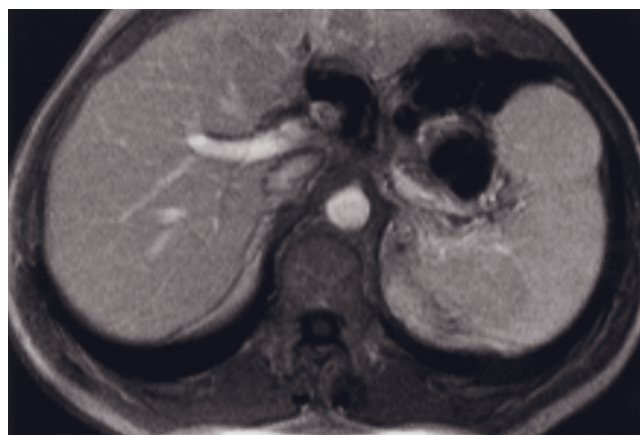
Hamartoma. Coronal T2-weighted single-shot echo-train spin-echo (*a*), T2-weighted fat-suppressed single-shot echo-train spin-echo (*b*), T1-weighted SGE (*c*), immediate postgadolinium T1-weighted SGE (*d*), and late postgadolinium T1-weighted fat-suppressed spin-echo (*e*) images demonstrate a lesion in the spleen that is moderately high in signal intensity on T2-weighted images (*a*, *b*) and isointense on T1-weighted image (*c*). The lesion enhances heterogeneously on immediate postgadolinium SGE image (*d*). On delayed image (*e*) enhancement becomes more homogeneous and is greater than that of background spleen. T1-weighted SGE (*f*), T2-weighted fat-suppressed spin-echo (*g*), and immediate (*b*), 90-s (*i*), and 10-min (*j*) postgadolinium images
